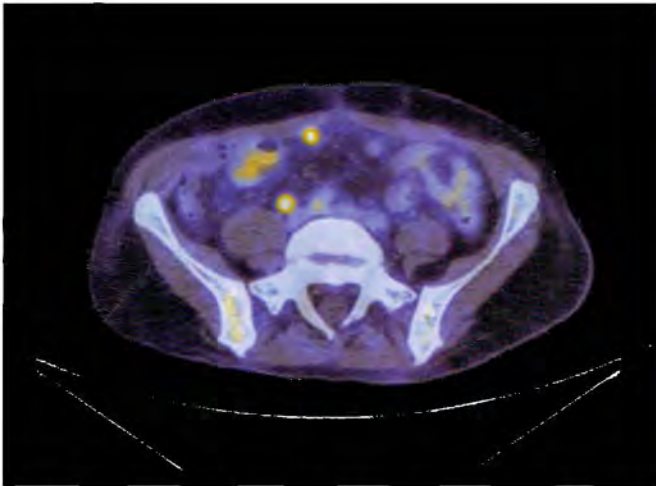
The metastatic lesion in the right iliac bone has a SUVmax of 8.9.
